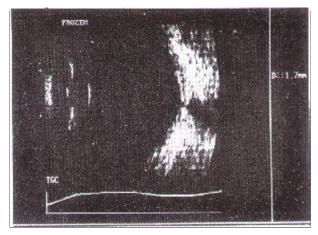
Ultrasonography of right eye showing decreased choroidal thickening (1.7 mm) following 3 doses of IVMP therapy.
